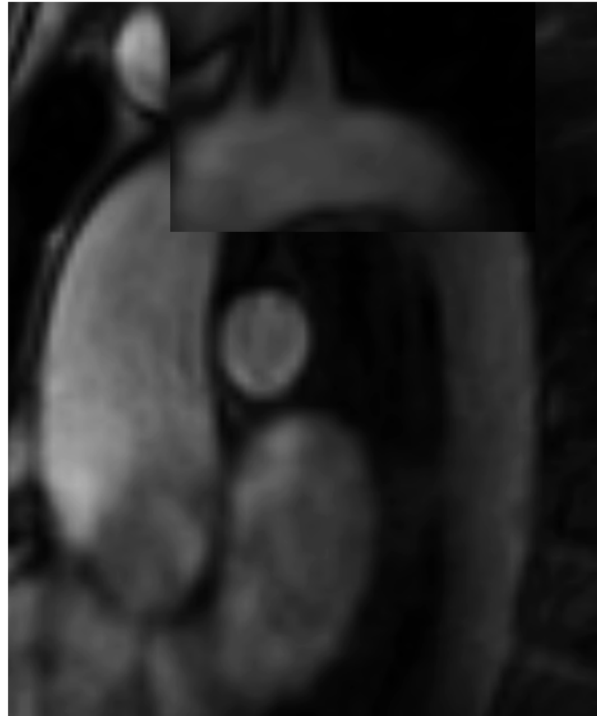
Visualization of D4 aorta with MRI using Mass.
